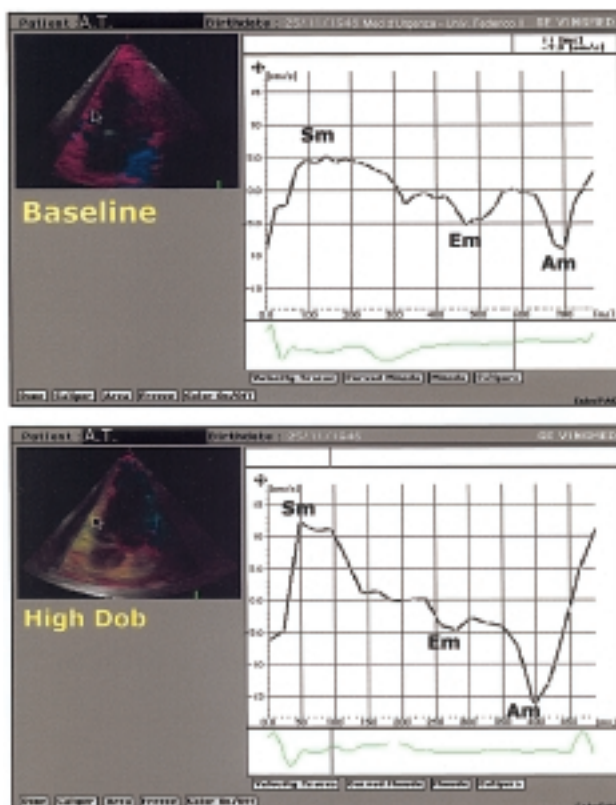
Color Doppler tissue imaging of the posterior septum at baseline (upper panel) and at high-dose dobutamine (lower panel) in a hypertensive patient. From baseline to high-dose dobutamine, we can observe a great increase in the S_m and A_m peak velocities while the E_m peak velocity remains almost unchanged. A_m = myocardial atrial velocity, E_m = myocardial early diastolic velocity, S_m = myocardial systolic velocity.
